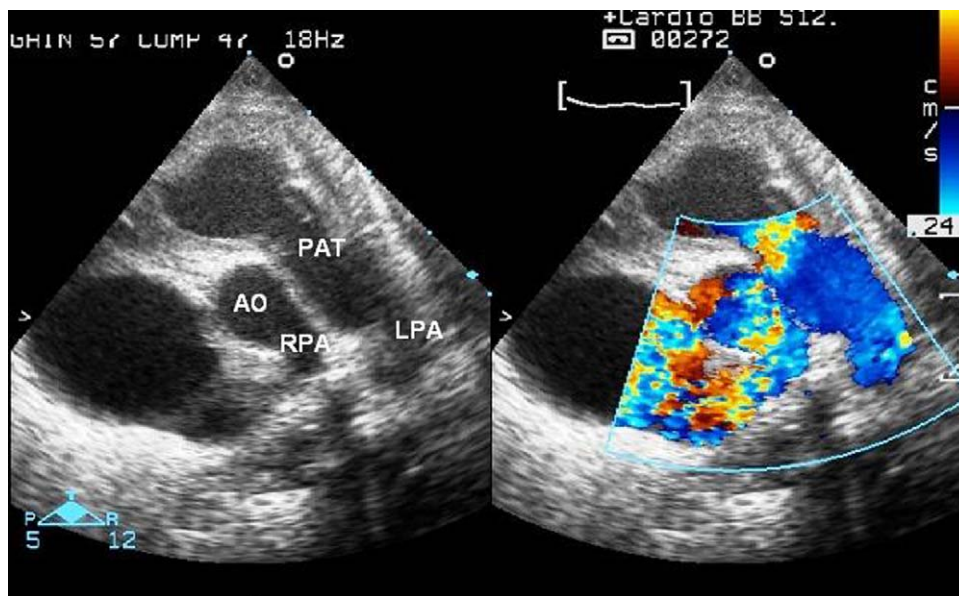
Parasternal short-axis view without (left) and with colour Doppler (right). The right pulmonary artery arises from the aorta while the left pulmonary artery arises from the pulmonary trunk. Ao: aorta; LPA: left pulmonary artery; PAT: pulmonary artery trunk; RPA: right pulmonary artery(Supplementary data).
